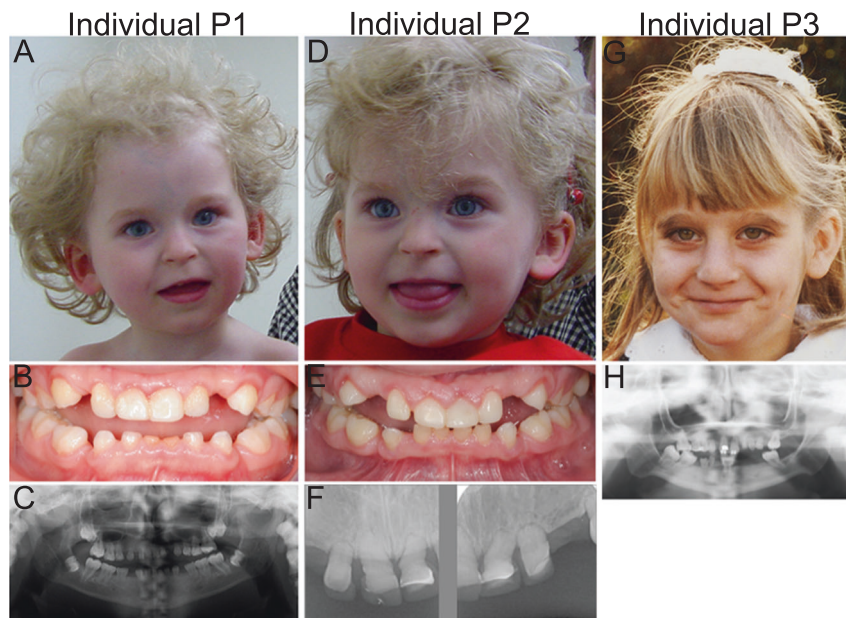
Facial appearances and dental abnormalities of the three individuals carrying biallelic *POLR3GL* variants. a Photograph showing the facial characteristics of individual P1 at the age of 3 years including upslanting palpebral fissures, thin lips, a flat philtrum and relatively long columella. b Intra-oral photograph of dental abnormalities of individual P1 showing an anterior open bite extending to the buccal teeth whereby only the most distal molars occlude. The central lower deciduous teeth are worn because of prolonged use. c Orthopantomographic radiograph of the full dentition of individual P1. The Orthopantomograph shows that the permanent dentition consists of the first and second molars, all other teeth are congenitally absent. In addition, it shows that the upper- and lower molar pulp chamber have a taurodontic shape. d Photograph of the face of individual P2 at the age
